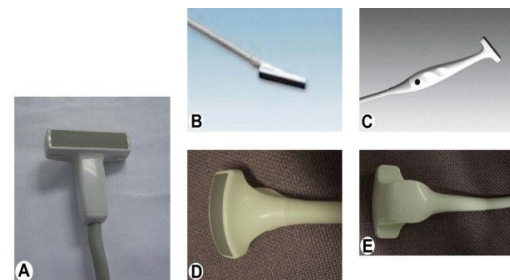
Intraoperative ultrasound probes: (a) T probe; (b) 'T' shaped array; (c) an end-firing array; (d) a curved array, particularly useful for hepatic scanning and (e) the back of the curved array is shaped to take the sonographer's fingers[11]
